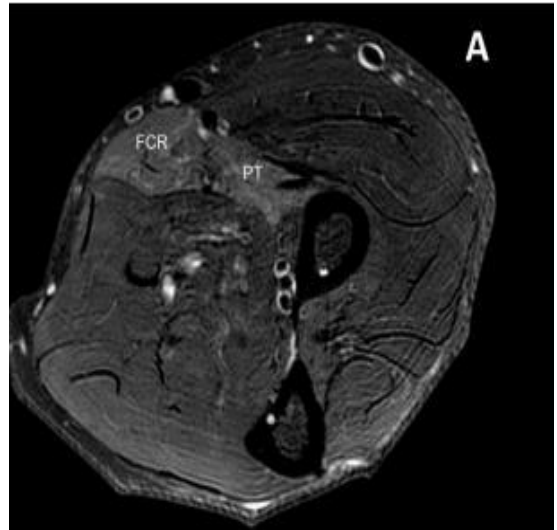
It demonstrates the pattern of denervation edema of the pronator teres (PT) and flexor carpi radialis (FCR) muscles. T2-weighted gradient echo axial image
